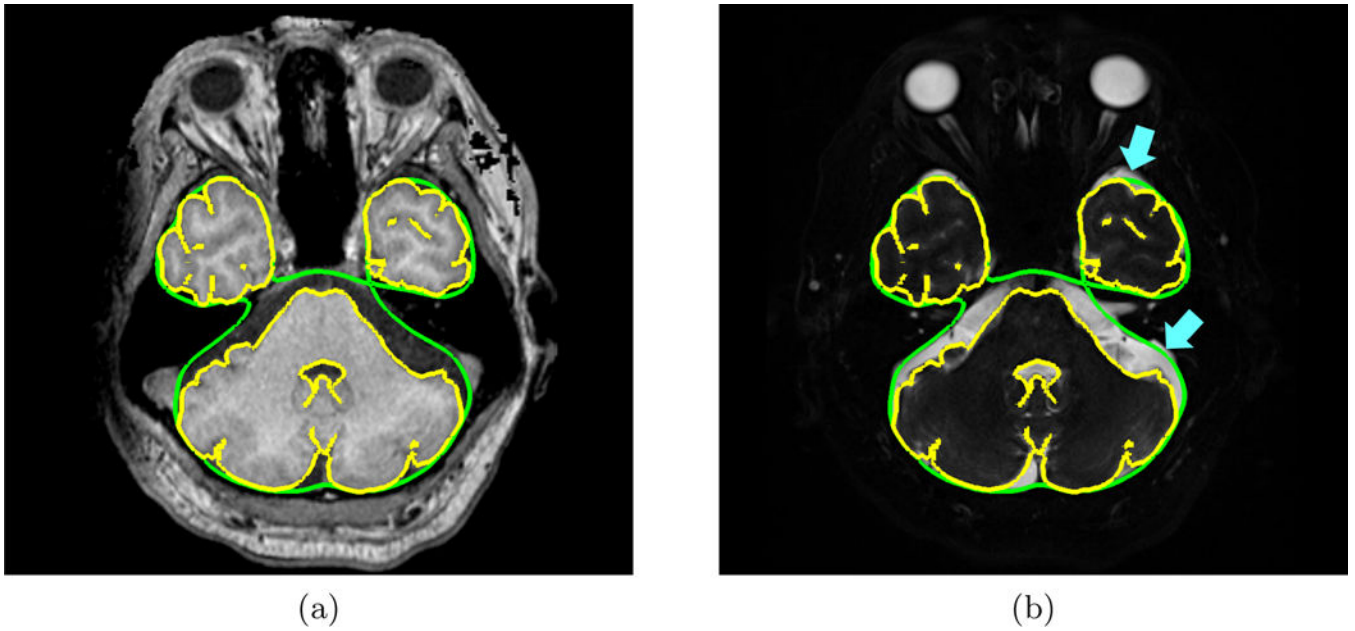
Axial view of an inferior slice of an NPH subject's (a) T1-w MRI and (b) T2-w MRI with the inner subarachnoid space surface (yellow contour) and outer subarachnoid space (green contour) overlaid. The blue arrows point to areas of CSF in the inferior region of the head that were not included in the subarachnoid space generated by the proposed method.
